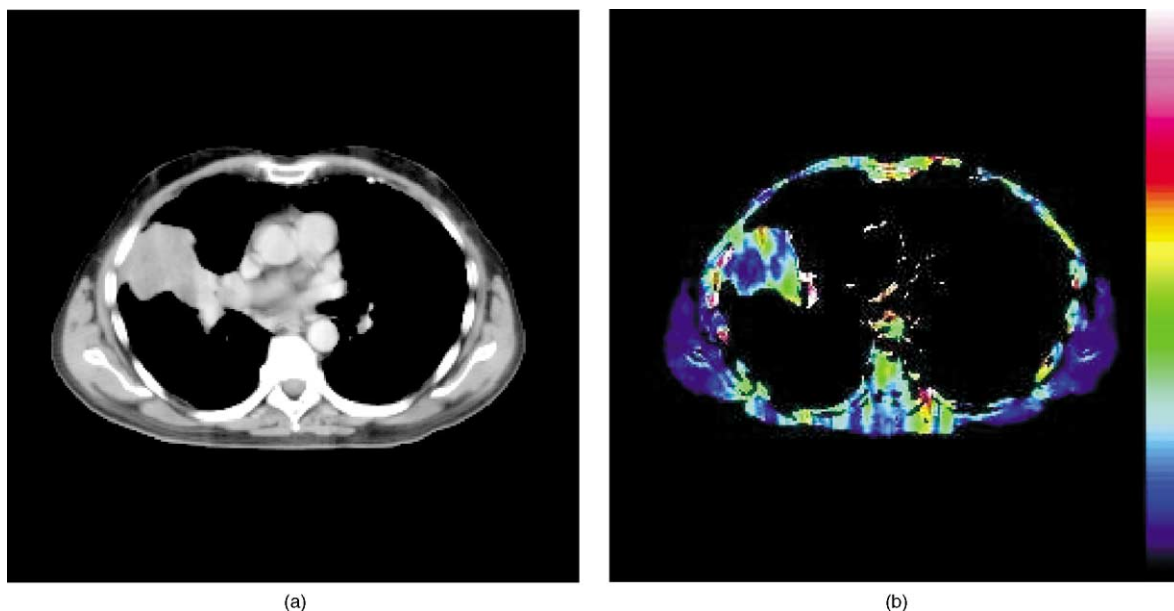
Contrast enhanced Computed Tomography (CT) (a) and perfusion CT (b) from a patient with a right-sided lung cancer. The degree of contrast enhancement and perfusion is determined by angiogenesis, enabling distinction between benign and malignant lung lesions and providing prognostic information.
